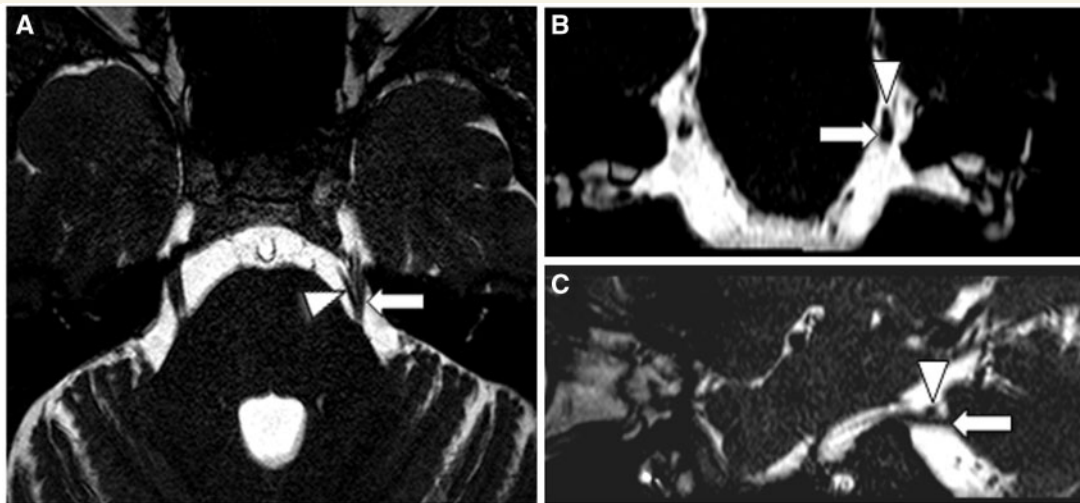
Simple neurovascular contact. MRI balanced fast field echo with axial (A), coronal (B) and sagittal (C) planes of the posterior fossa showing simple neurovascular contact between the left trigeminal nerve (arrows) and the left superior cerebellar artery (arrowheads) in the root entry zone. Patient suffers from left-sided trigeminal neuralgia.
